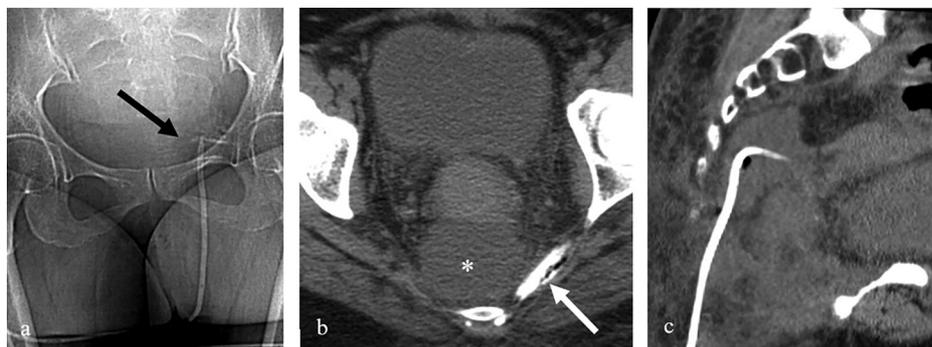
A 53-year-old woman who underwent abdominoperineal resection. Failed fluoroscopy-guided drainage and followed by successful CT-guided drainage: a: scout image after fluoroscopy-guided drainage shows misplaced drainage catheter (black arrow) left lateral to the sacrum; b: CT image in the axial plane shows contrast material and iatrogenic air in the piriformis muscle (white arrow) injected during the fluoroscopy-guided drainage-attempt, lateral to the presacral abscess (white asterisk); c: CT image in the sagittal plane after successful repeat CT-guided transperineal catheter placement shows the catheter in the centre of the abscess.
